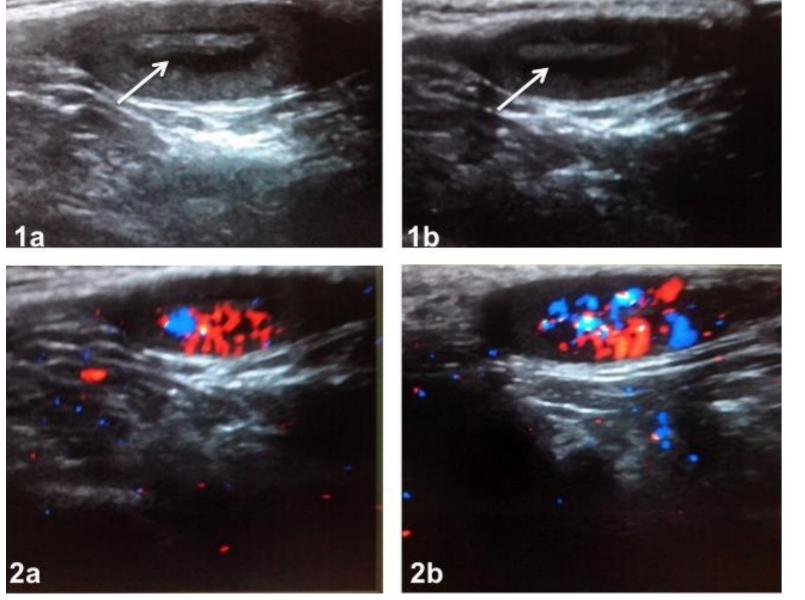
Longitudinal testicular ultrasound and color Doppler images of a 1.8 years old boy with salt wasting form of congenital adrenal hyperplasia. Arrows indicate bilaterally slightly lobulated well defined hypoechoic masses with central hyperechoic part in the area of rete testes measuring 1.1 X 0.6 X 0.4 cm =0.13 ml (1a right testis) and 1.0 X 0.6 X 0.4 cm = 0.12ml (2a left testis). The masses identified as testicular adrenal rest tumors are hypervascular (1b right testis and 2b left testis). Tanner V=1.4-7.5; ²LH: Tanner I: <0.1-0.9; Tanner II: Tanner III: 0.5-5.4; Tanner IV 1.1-5.8; Tanner V 1.5-6.3; ³Testosterone: Tanner I <0.1-0.3; Tanner II 0.6-5.2, Tanner III 3.5-11.1; Tanner IV 6.9-21.5; Tanner V 12.1-28.5; ⁴17-OHP (17-hydroxyprogesterone): 0.9-4.5; ⁵Androstenedione: 2-6.9 y=0.2-0.6; 7-10 y= 0.3-1,7; Tanner II 0.4-2.5; Tanner III 1.7-5.9; Tanner IV 1.6-7.2; Tanner V 1.8-7.8; ⁶Plasma renin activity (PRA): 0.2-2.8; ⁷Inhibin B (32): Tanner I=35-182; Tanner II=62-338; Tanner III=78-323; Tanner IV=67-304; Tanner V=95-323; ⁸L: left; R: right; ⁹Classification of TART according H.L.Claahsen-van der Grinten et al. JPEM 1994
